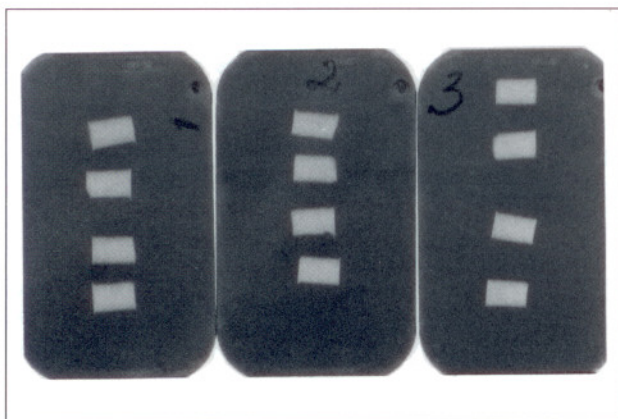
Radiographs of the controls (no. 1), samples heated to 370°C for 5 minutes (no. 2) and heated to 500°C for 5 minutes (no. 3). The materials from the top are: Dyract, Fuji, TPH, Z-100.
